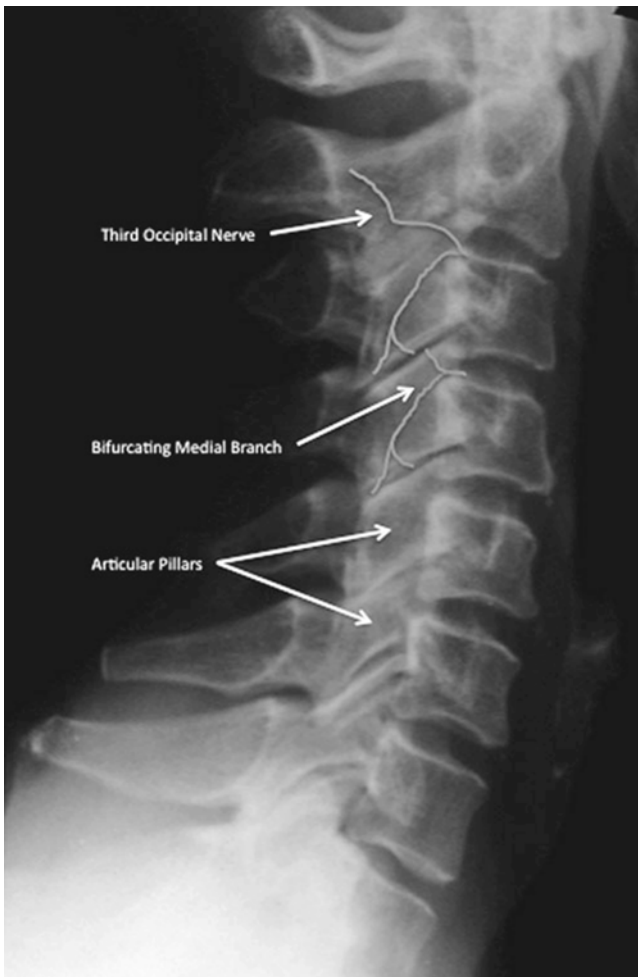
Lateral radiograph of cervical spine identifying the articular pillars, demonstrating the bifurcation of the medial branch at C4 for a dual innervation pattern and the course of the third occipital nerve
